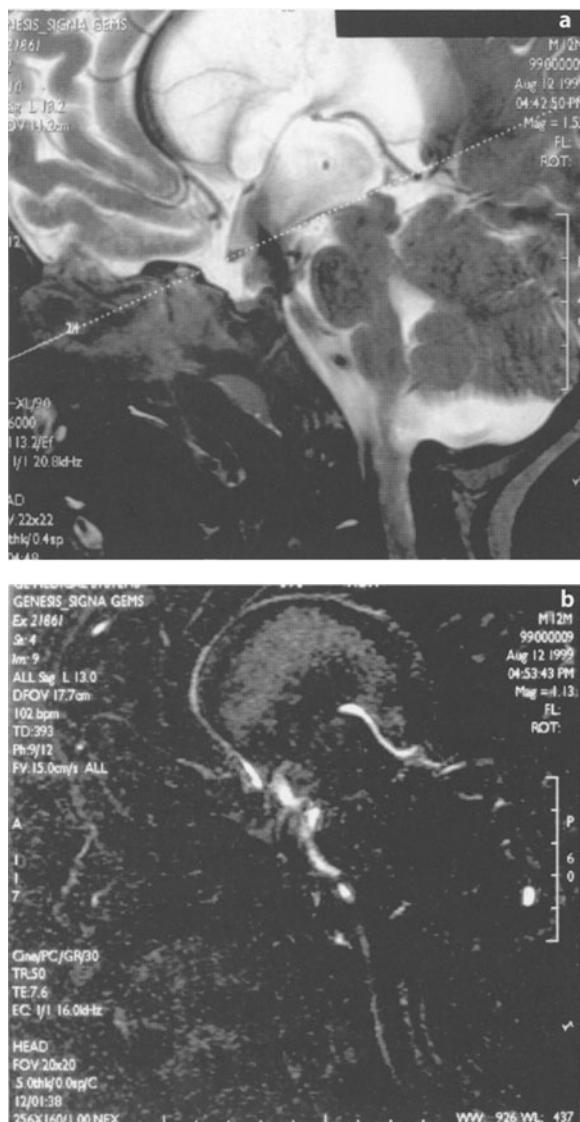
a A 1-year-old baby girl with an aqueductal stenosis treated by ventriculocisternostomy. The flow is visible in the region of the floor of the fourth ventricle on the sagittal T2-weighted image. b On cine PC imaging the flow is visible as a white ribbon. It is descending during systole. The flow is also visible as well in the cervical spine
